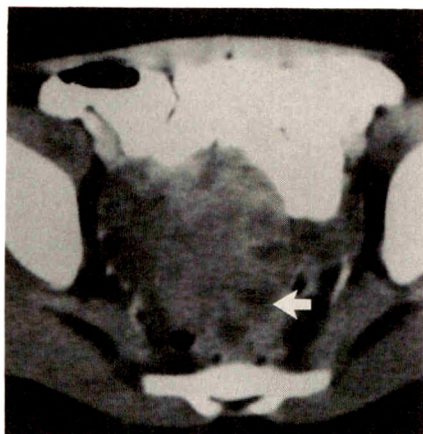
Case 1: Contrast-enhanced CT shows a large, complex pelvic mass with multiple peripheral foci (arrow) of low attenuation. Opacified pelvic vessels can be seen draped around mass.
